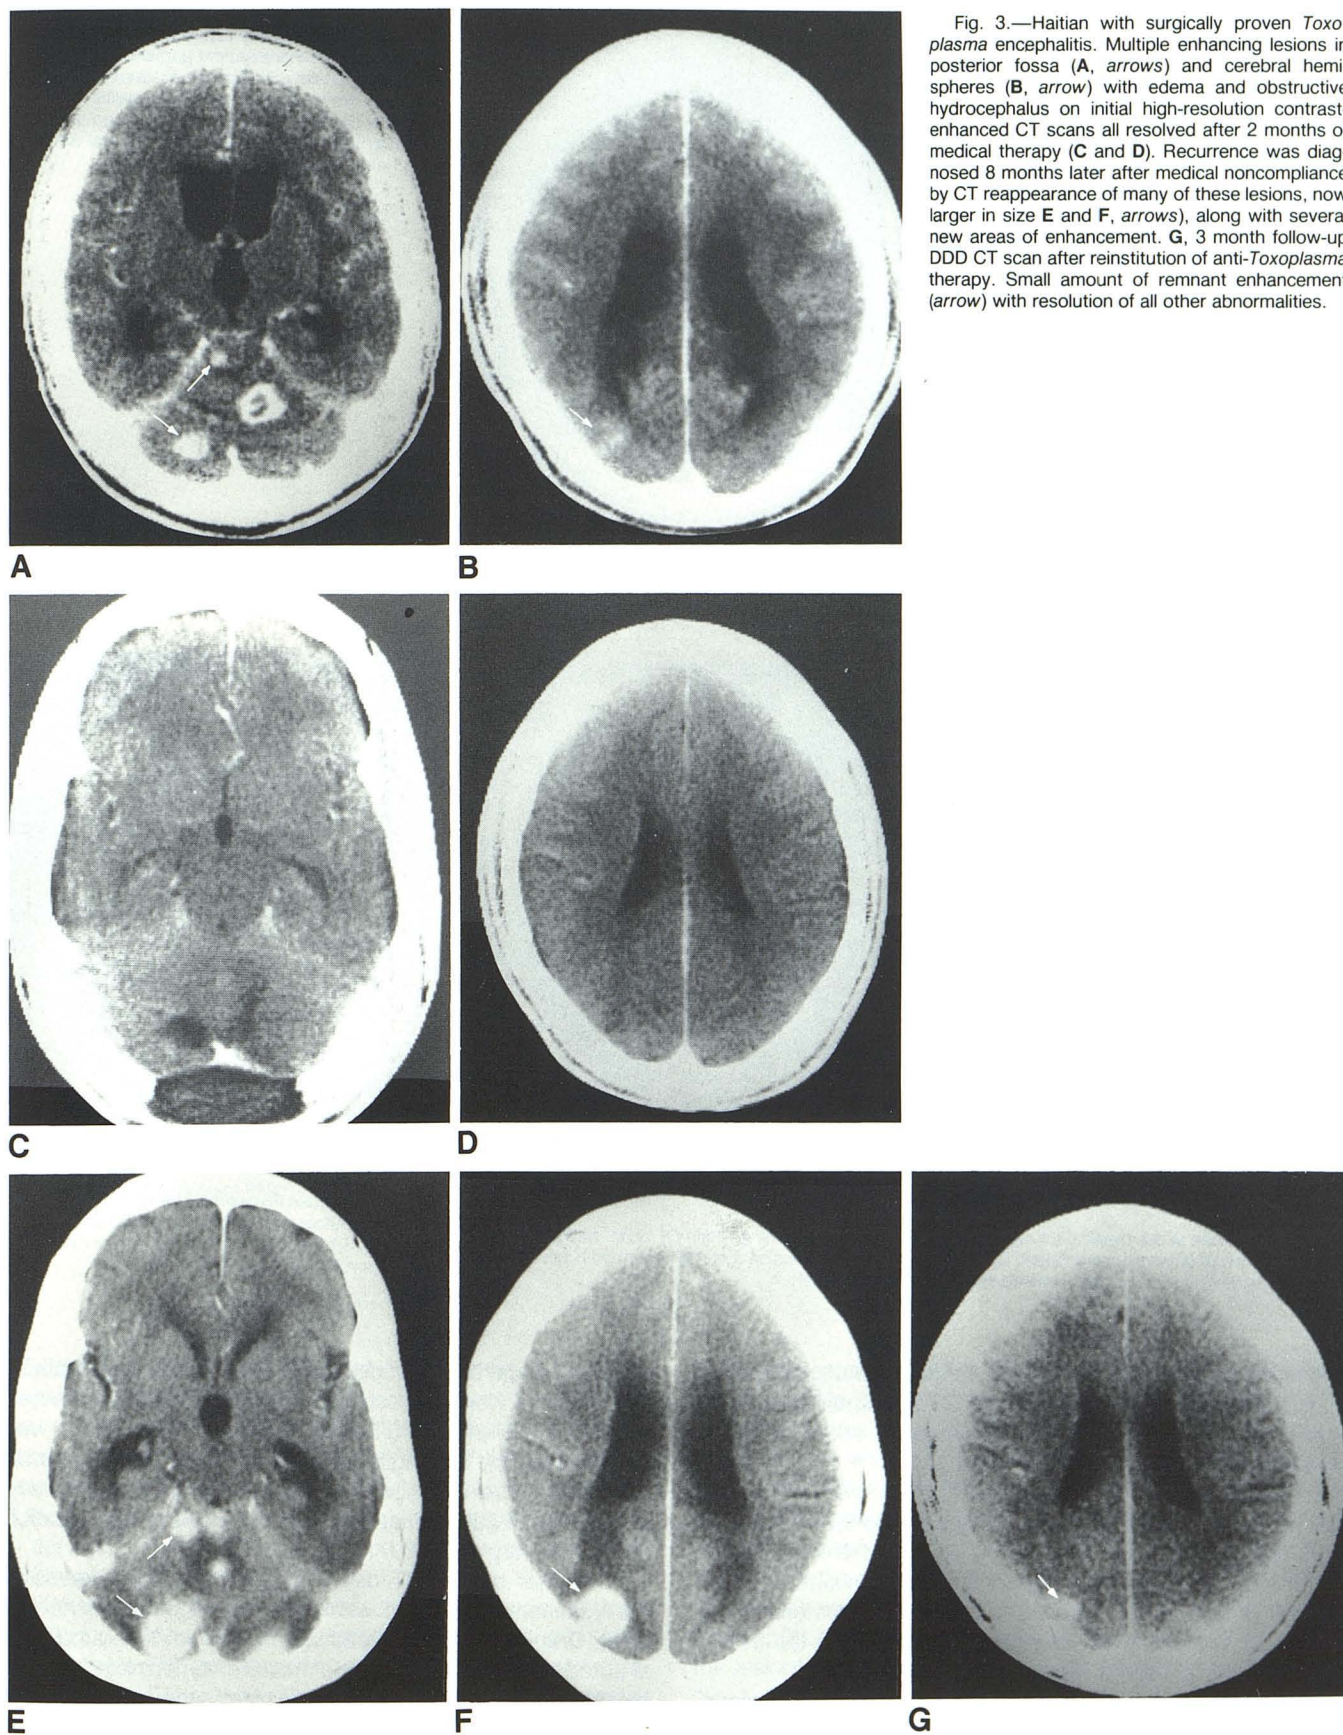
Haitian with surgically proven *Toxoplasma* encephalitis. Multiple enhancing lesions in posterior fossa (A, arrows) and cerebral hemispheres (B, arrow) with edema and obstructive hydrocephalus on initial high-resolution contrast-enhanced CT scans all resolved after 2 months of medical therapy (C and D). Recurrence was diagnosed 8 months later after medical noncompliance by CT reappearance of many of these lesions, now larger in size E and F, arrows), along with several new areas of enhancement. G, 3 month follow-up DDD CT scan after reinstitution of anti-*Toxoplasma* therapy. Small amount of remnant enhancement (arrow) with resolution of all other abnormalities.
